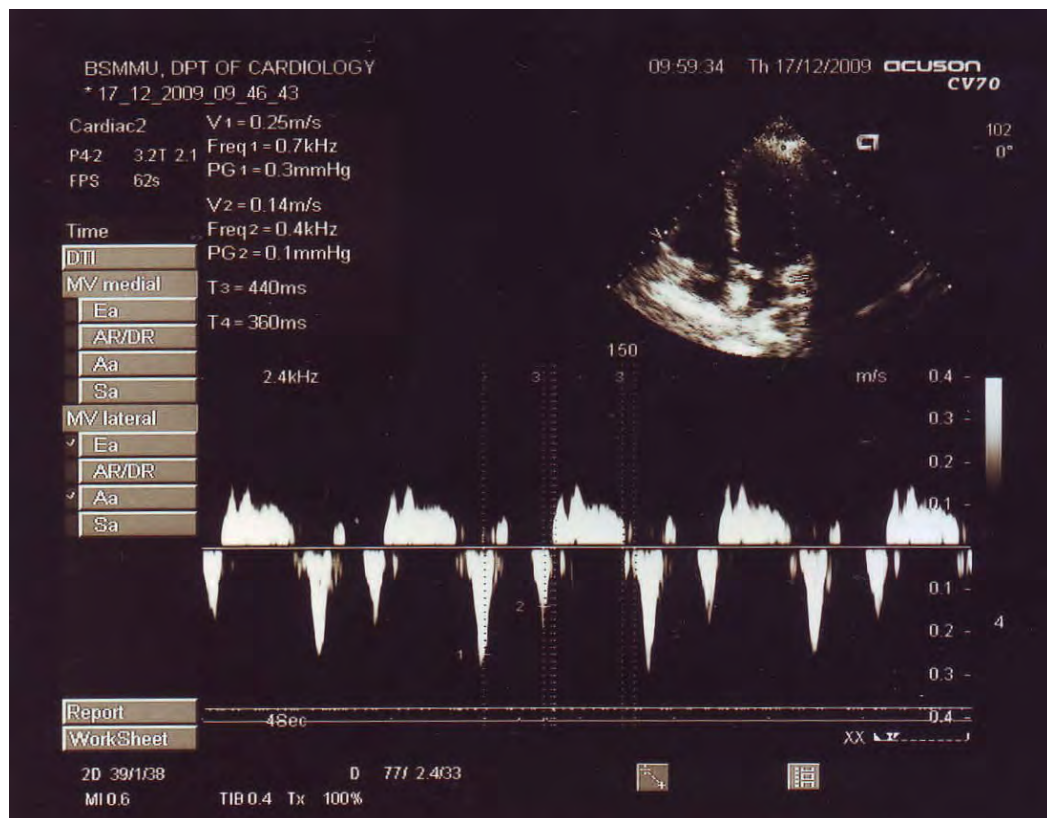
Normal pattern of Tissue Doppler Imaging in lateral wall of mitral annulus showing Em (25 cm/sec) and Am (14 cm/sec) waves.
